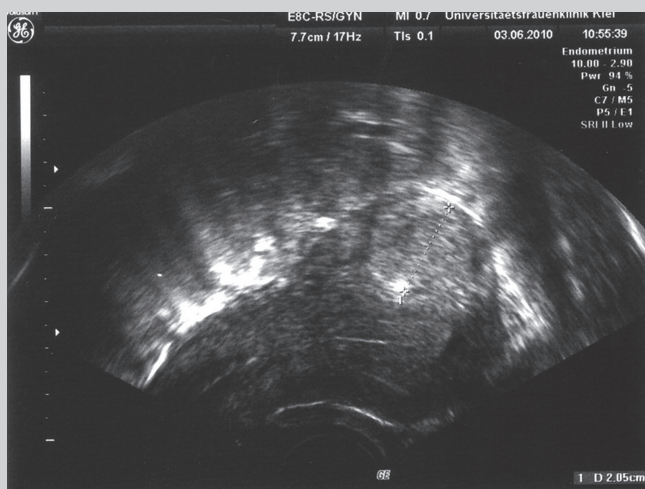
Preoperative transvaginal ultrasound scan showing the typical misleading sonographic picture of a fibroid (Case 1)
